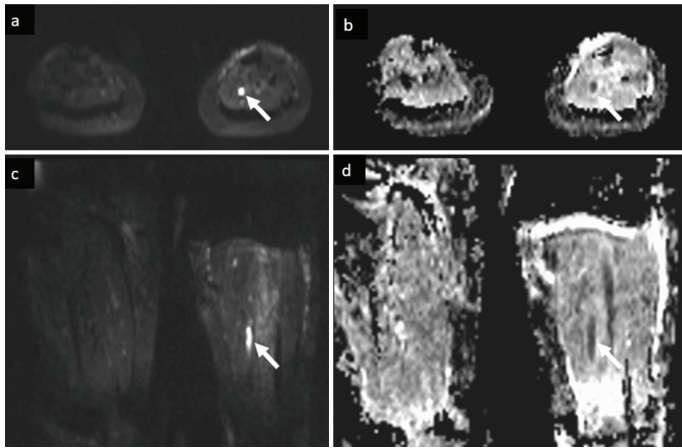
DWI (b=800) with ADC map defines acute thrombosis of posterior tibial vein as restricted diffusion on axial (a,b) and coronal (c,d) images
